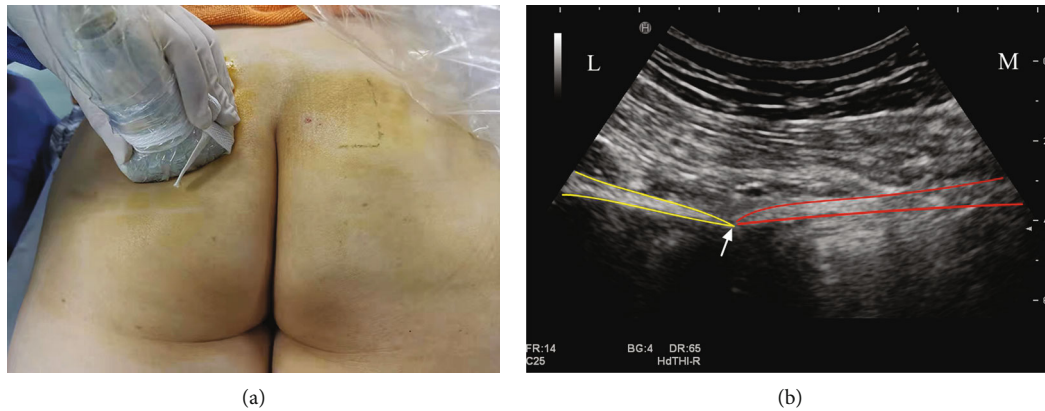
Diagnostic block of the pudendal nerve under ultrasound guidance. (a) Position and direction of the ultrasonic probe. (b) Transverse section of the ultrasound image in the ischial spine. Red outline: sacrospinous ligament; yellow outline: ischium; white arrow: ischial spine. L: lateral; M: medial.
